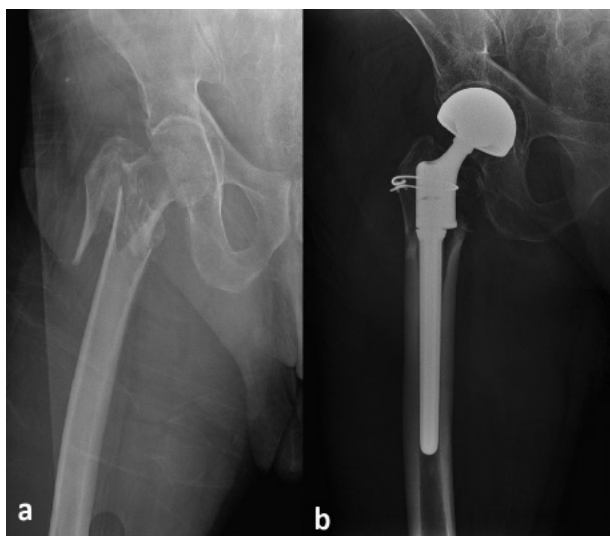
Anteroposterior radiographs of our 76-year-old male patient (a) before and (b) after hemiarthroplasty with distal intramedullary fixation. The femoral stem has been fixed in the medullary canal press-fit.
